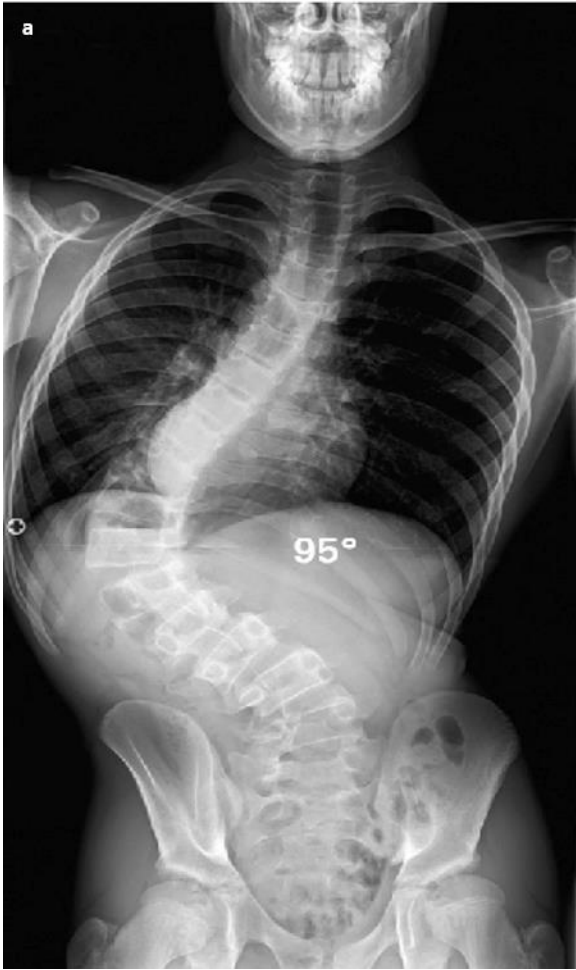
A) Posteroanterior and B) lateral radiograph of 13 year-old-male presenting with a severe left thoracolumbar scoliosis (Tsirikos and Smith, 2008).
